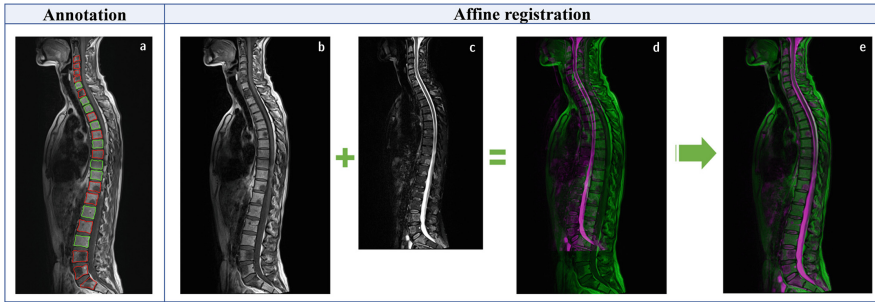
(a) Example of vertebra annotations of a central slice from T1-MRI: healthy vertebra in green and pathological vertebrae in red. Affine Registration on two MR central slices: (b) T1 and (c) T2, of a patient with multiple metastases. (d) Shows an overlay of the input images. (e) Shows the final result, T1 in green and T2 (transformed) in purple (Color figure online)
